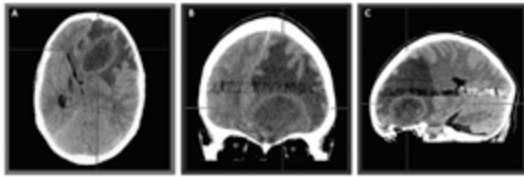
Clinical example Argemiro CT series showing Argemiro's frontal abscess.
